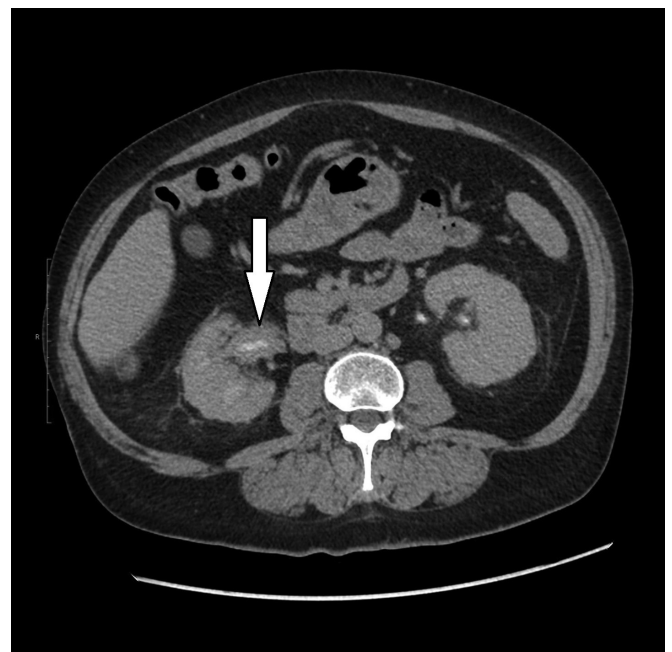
CT scan revealing thickened walls of the right renal pelvis
